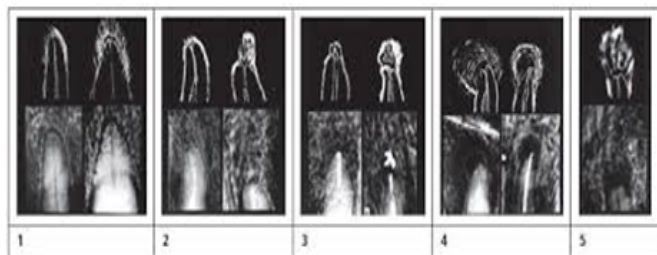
Reference radiographs, simplified, drawn images and PAI scores
